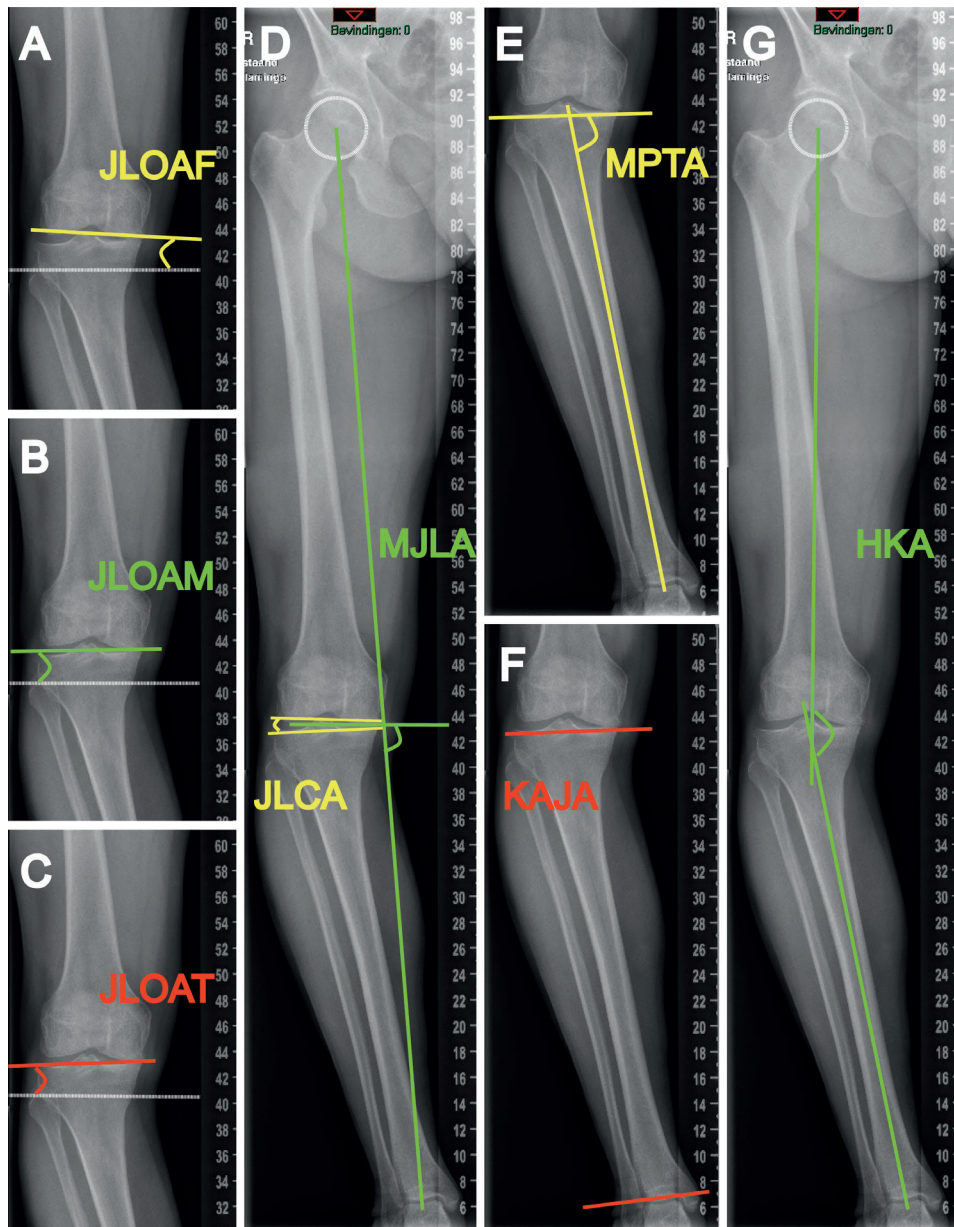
Measurements in anteroposterior long single-leg standing radiograph
